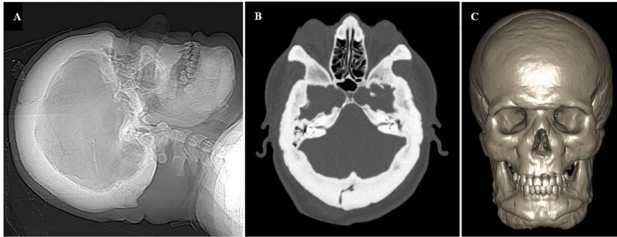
A) CT scanogram of the skull (lateral view) shows extensive sclerosis of the calvarium, maxillae and mandible. B) CT scan at the level of the posterior cranial fossa detects a marked thickening and sclerosis of the skull bones with narrowing of the internal auditory canals. C) 3D Volume Rendering of Spiral CT Data.
